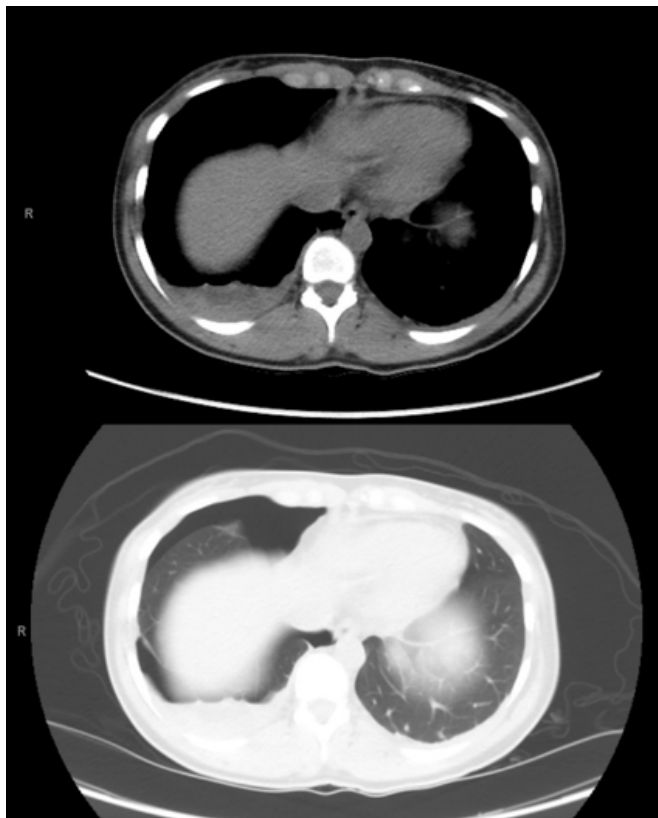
Presenting CT scan showing small right sided effusion and pneumothorax.
